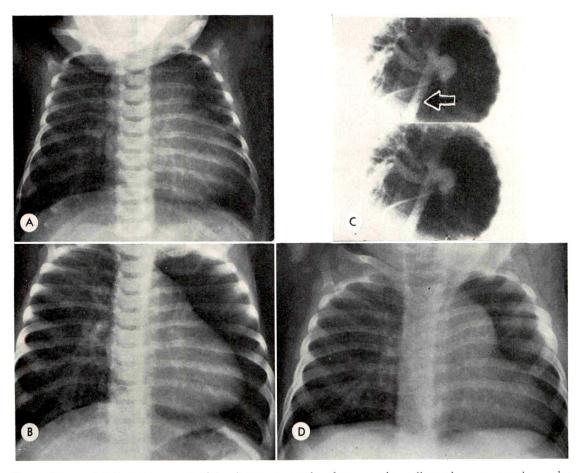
Case II. (A) Roentgenogram of the chest at 2 months of age reveals cardiac enlargement and vascular overfilling in both lungs. (B) At 4 months of age, there was a definite difference in the vascularity of the lungs; the intrapulmonary vessels on the right are engorged, while those on the left are normal in size and distribution. (C) Cineangiocardiograms made during injection of contrast material into the pulmonary artery reveal filling of this structure and the aorta (arrow). Two branches of the pulmonary artery go to the right lung. There is less opacification of the branches of the pulmonary artery to the left lung than of those to the right one. (D) Roentgenogram of the chest made 2 months postoperatively reveals equal aeration of, and vasculature within, the lungs.
